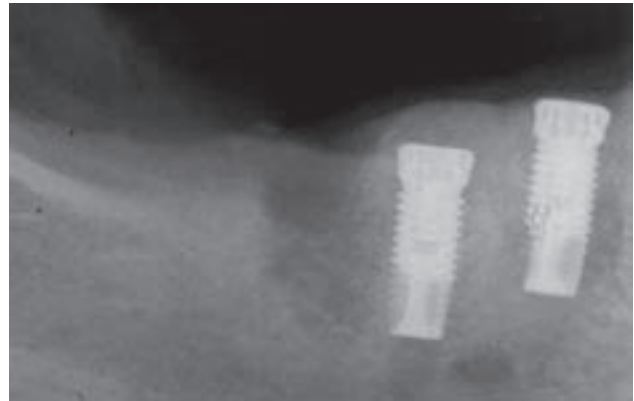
A 64-year-old woman with a history of breast cancer. The patient was treated with chemotherapy and intravenous bisphosphonates, approximately 3 years before placing the implants and extracting the teeth. The radiograph demonstrates osteonecrosis.
